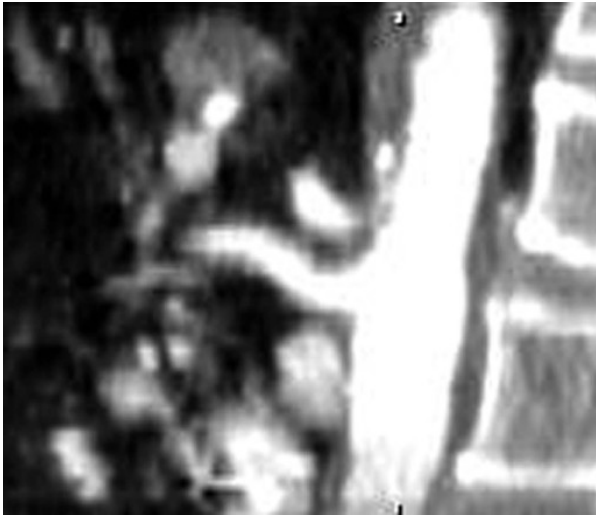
In retrospect re-evaluation of the preoperative CT of the abdomen showed notable stenosis at the origin of the celiac axis (sagittal multiplanar reconstruction image).
